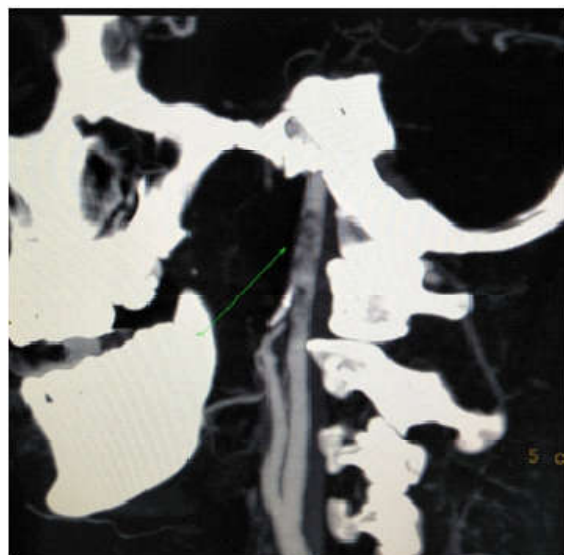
CT Angio Left side
